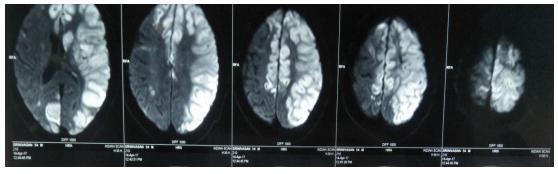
MRI brain axial DWI sequence showed high DWI signal (multiple infarcts) in the left anterior and middle cerebral artery, right anterior cerebral artery and bilateral posterior circulation territories.
